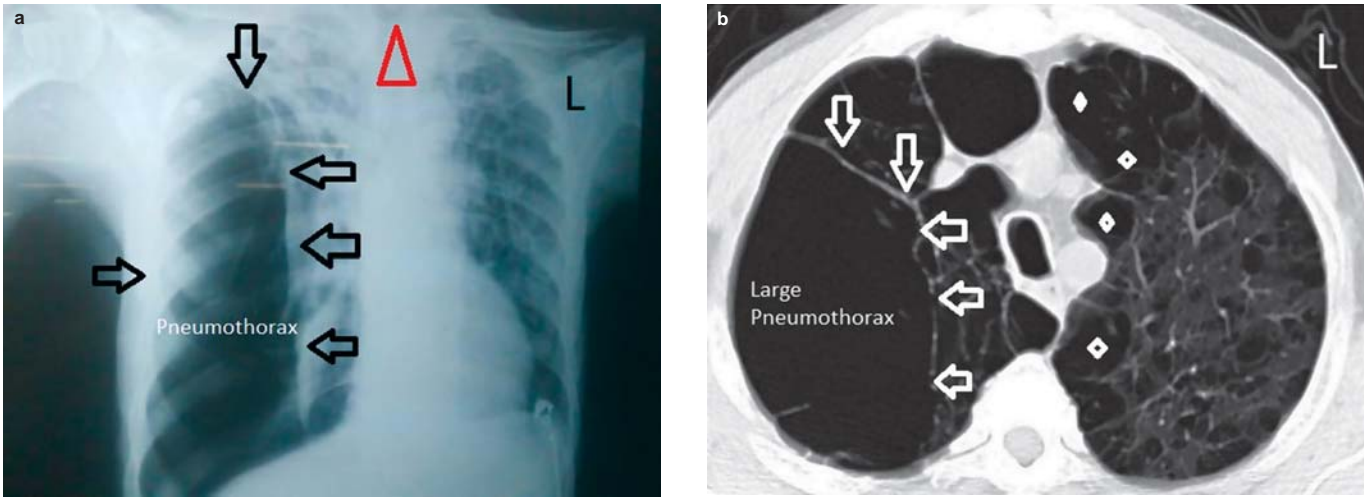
Chest X-ray and high-resolution computed tomography image showing right-sided pneumothorax: (a) black arrows pointing at large pneumothorax in the right lung; upward facing red arrowhead showing trachea pushed towards left; (b) white arrows pointing to pneumothorax and diamond white markings showing multiple bullae in the left lung
